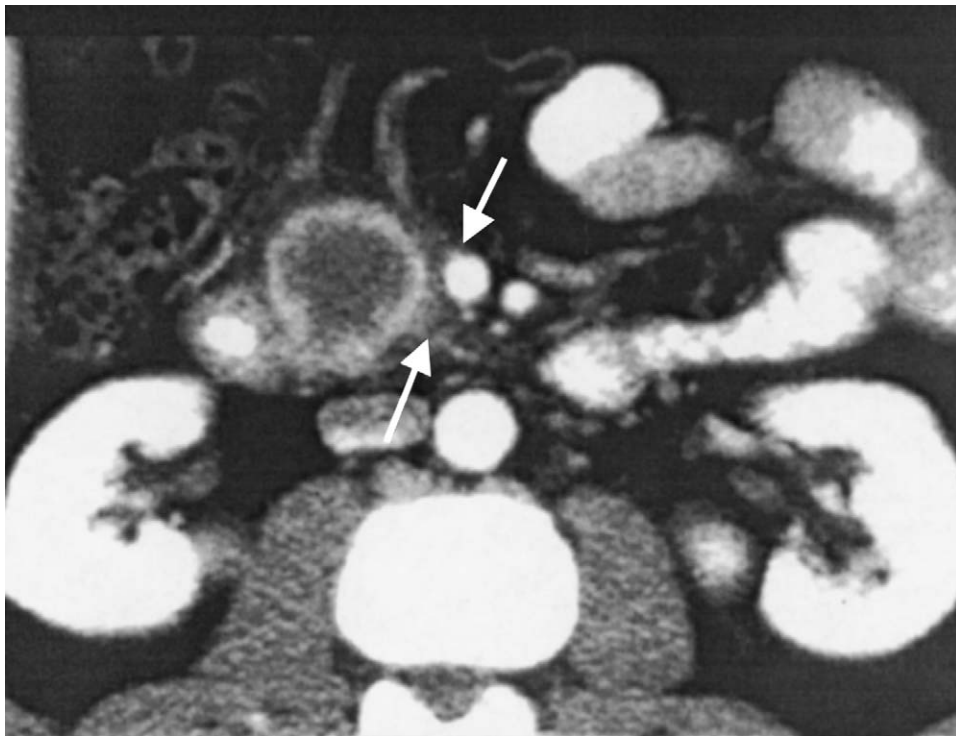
CT scan showing partial encroachment of SMV by tumor. (Courtesy of Saroja Adusumilli, Department of Radiology, The University of Michigan Medical Center).
